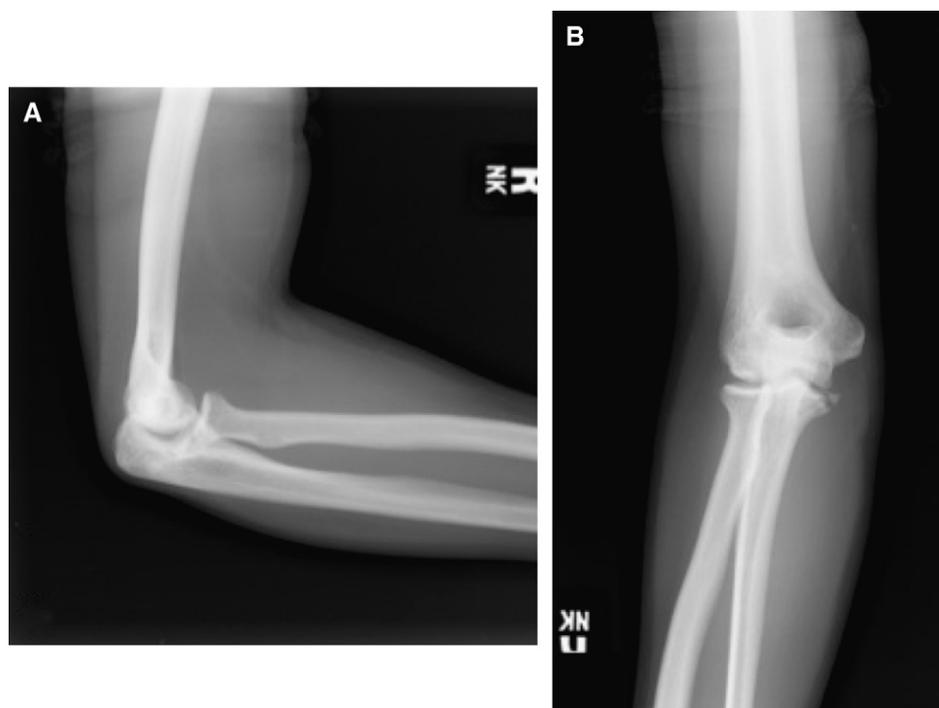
(A) Lateral and (B) anteroposterior radiographs of the right elbow 6 months postoperatively show evidence of calcification within the ulnar collateral ligament medially. The bony fragment is well approximated and united.
